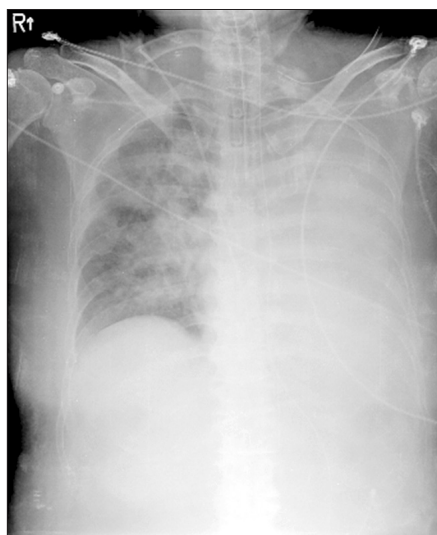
Chest radiography showed a completely opacified left hemithorax.
